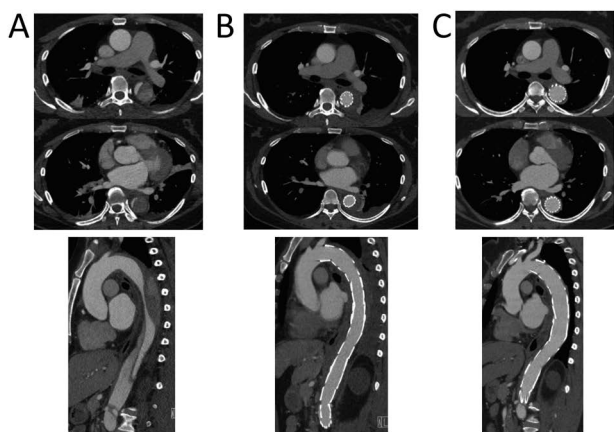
CT images of 44 year-old female diagnosed with acute complicated type B aortic dissection.
